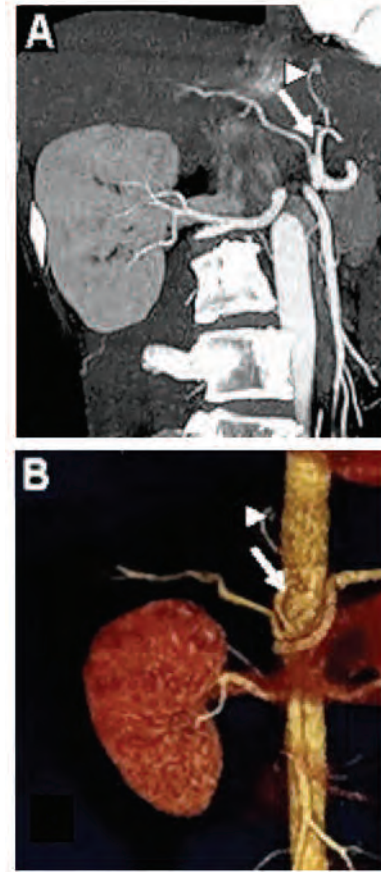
A and B. A 25-year-old male potential living-liver donor. Coronal maximum intensity projection (A) and volume-rendering (B) images based on computed tomographic studies obtained during the arterial phase show an accessory left hepatic artery (arrowhead) arising from the left gastric artery (arrow).
